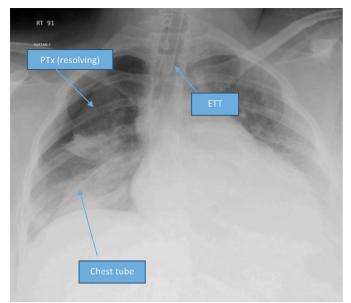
Post-intubation chest x-ray showing the right-sided resolving pneumothorax, with chest tube and endotracheal tube (ETT) in place (arrows).
